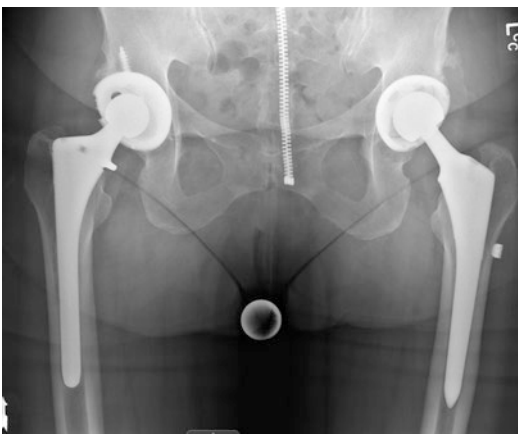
Postop radiograph showing the placement of radiolucent plastic cerclage cable on the left femur (right side of image) just below the lesser trochanter for fixation of intra-operative calcar fracture. The cable locking clamp can be visualized below the lesser trochanter, on the lateral cortex
